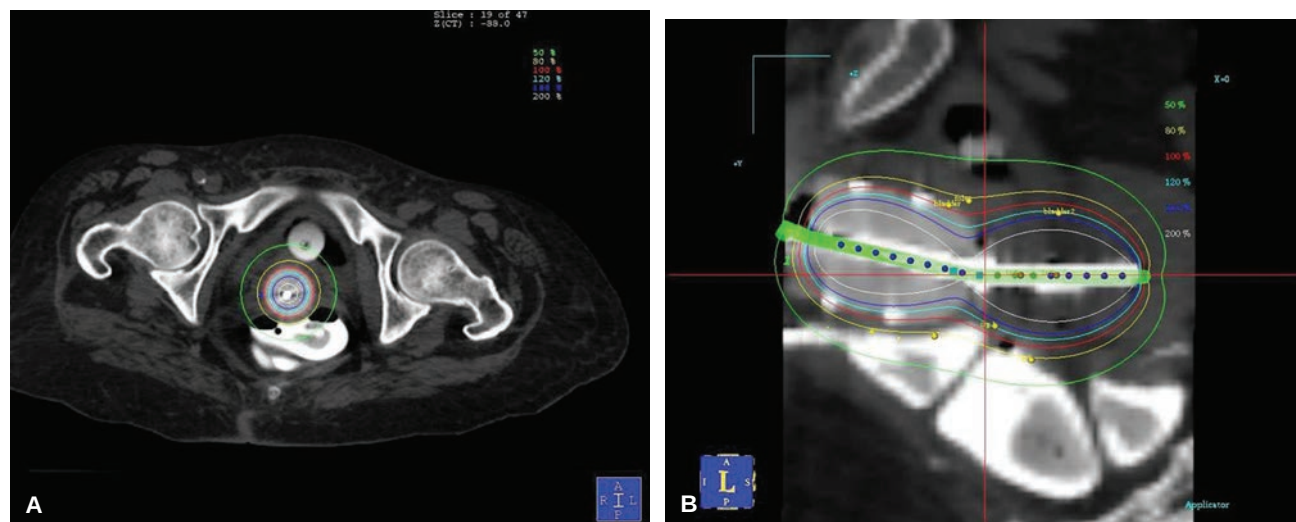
MRI/CT compatible tandem and cylinder applicator with associated isodose distribution in A: axial and B: sagittal views, demonstrating the close proximity to the rectum due to the absence of packing or rectal retraction.
